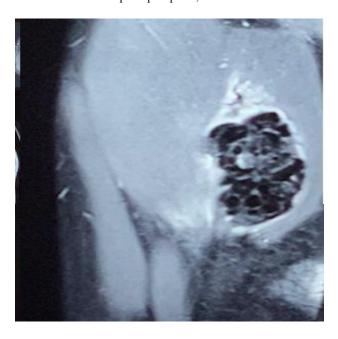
MRI of the hip showing 5.7×3.7×3 cm lobulated heterogeneous hypointensity near the left greater trochanter.
